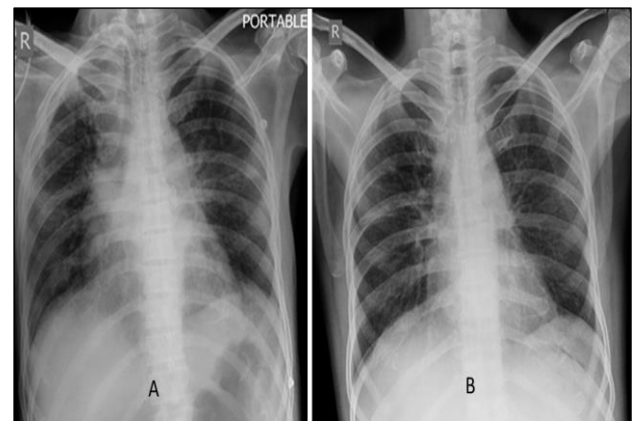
and 4B: X-Rays of the patient on admission (A) and after 9 days of treatment (B).
